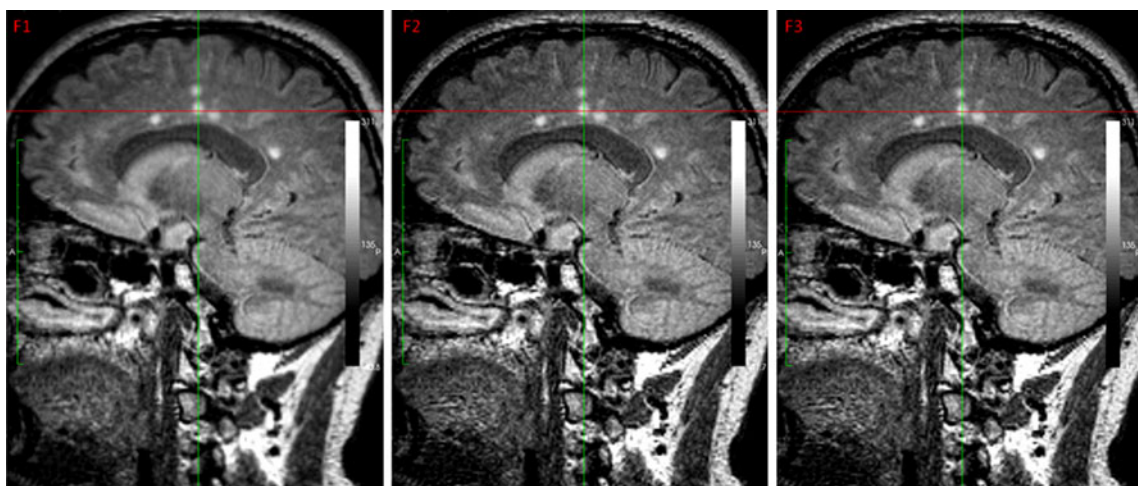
Sagittal FLAIR images of a 55-year-old woman with MS show multiple ovoid hyperintense lesions in the white matter with immediate contact to the lateral ventricles. Sagittal FLAIR images acquired at the beginning of the study ($F1$), after 1 month without
